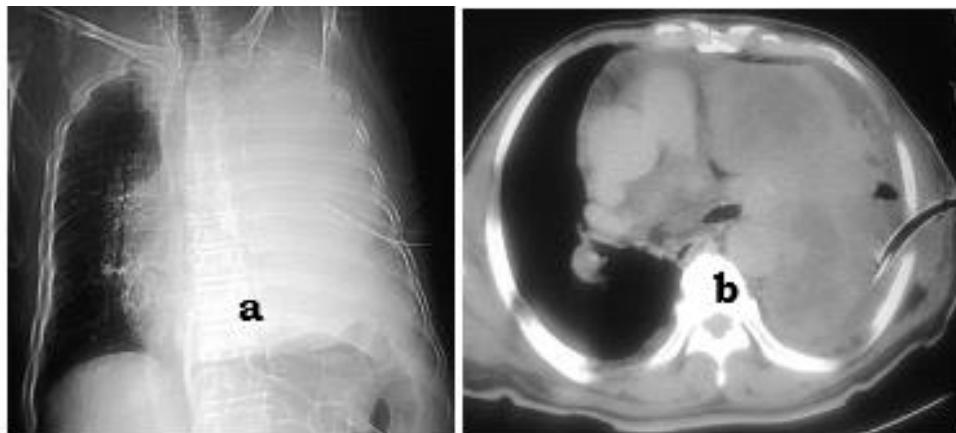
a. Chest radiograph showing complete opacity of the left hemithorax from bronchogenic carcinoma. b. Chest CT showing non-homogenous density due to left lung masses and pleural effusion. Note also a thoracotomy tube on the left.
